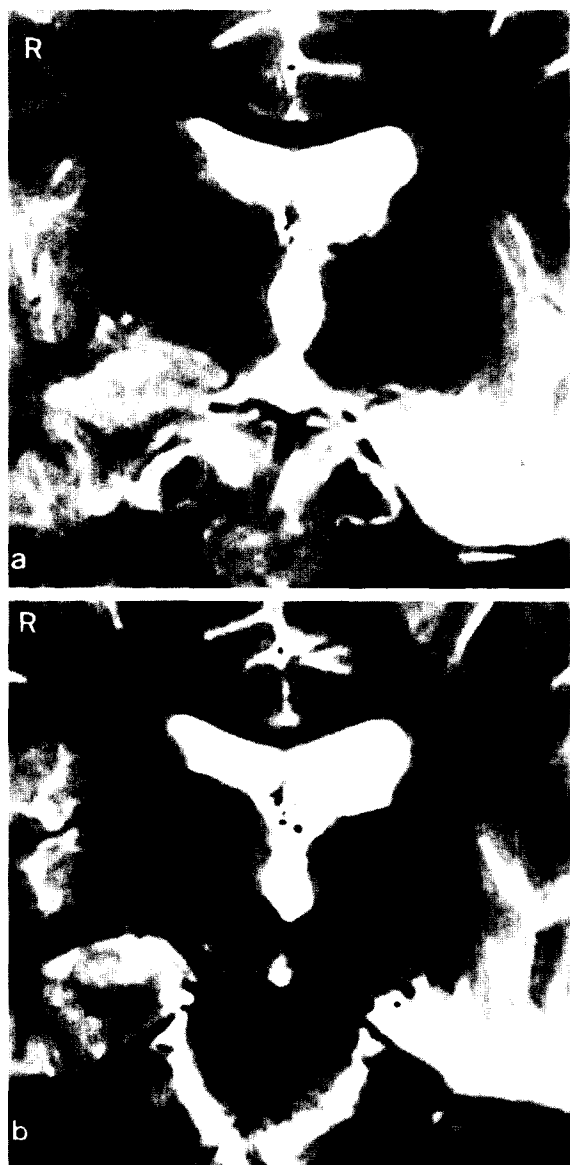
FSE T2W coronal MR images, approximately 3 months before the onset of severe amnesia, demonstrate the normal head (a) and body (b) of the right hippocampus (arrows). There has been a left-sided anterior temporal lobectomy, with removal of most of the hippocampus and entire amygdala.
